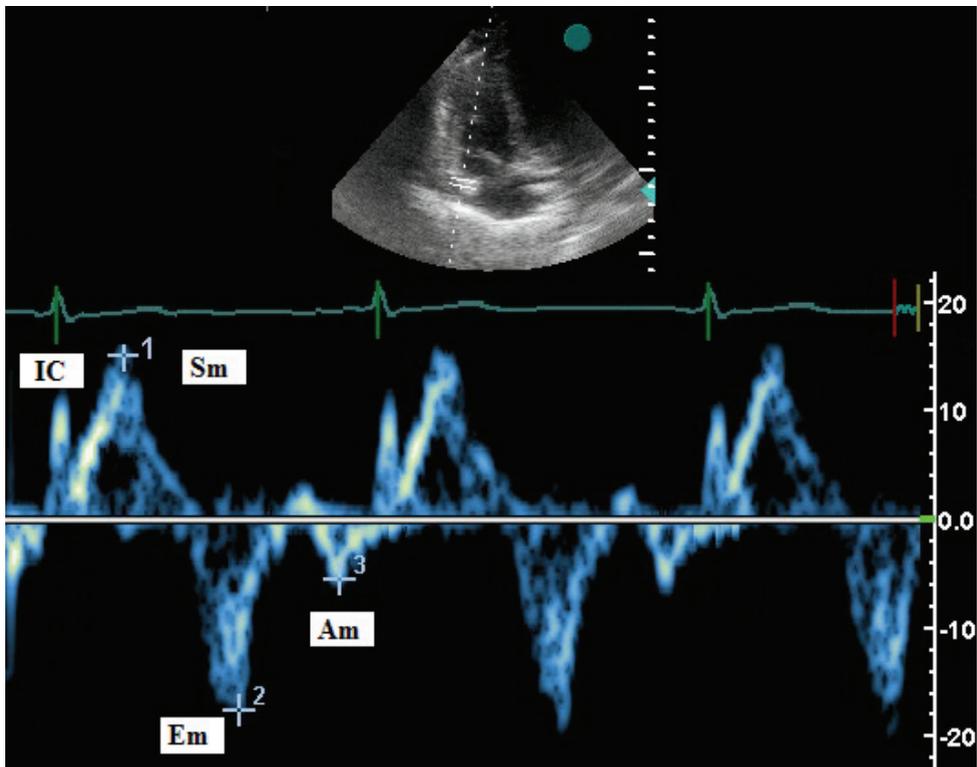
Tissue Doppler Imaging (TDI) velocities of tricuspid valve.
